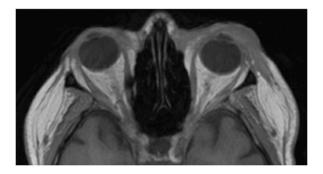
Magnetic resonance imaging (MRI) of the orbits. Axial T1/FLAIR sequences demonstrate left preseptal tissue thickening. There is no evidence of postseptal, intraconal or cavernous sinus abnormal enhancement. The MRI appearance suggests presence of a lymphoproliferative, infiltrative or metastatic process.
